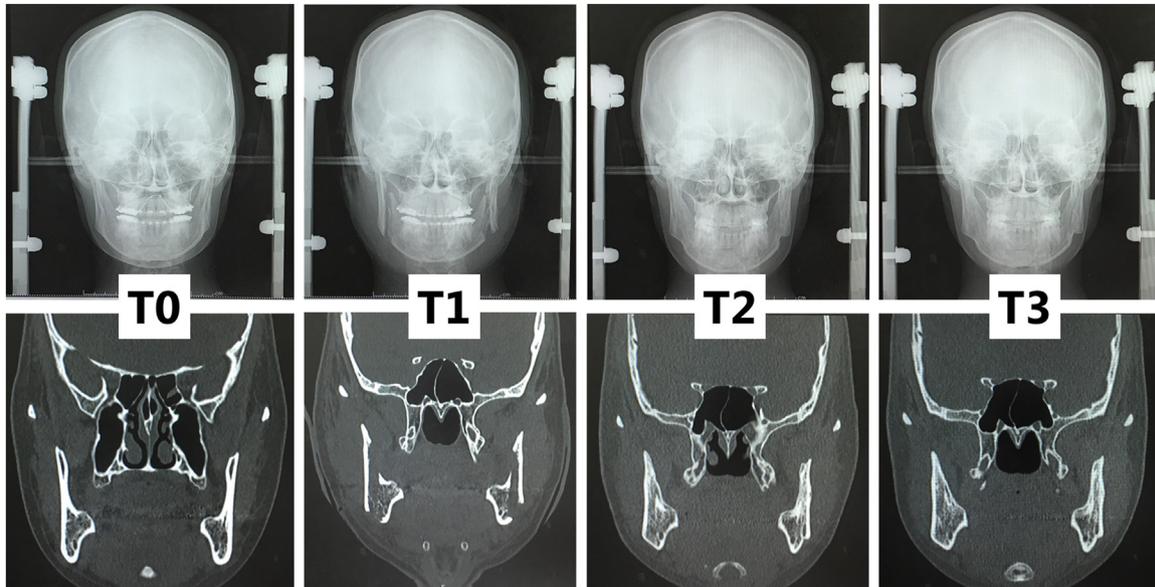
Radiographic findings from cephalometric photographs and computed tomographic scan.
